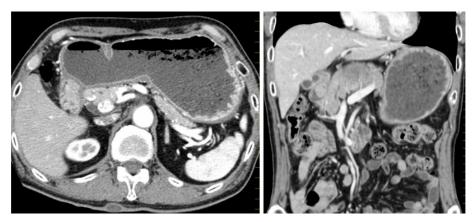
Contrast enhanced computed tomography (CE-CT). An image of a CE-CT demonstrating an enhanced lesion protruding into the lumen of a duodenal bulb. The stomach is extended with food residue.
